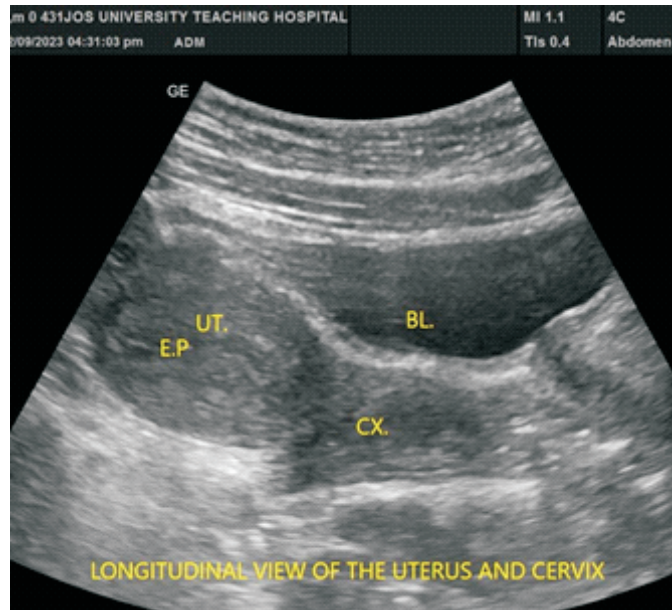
A grayscale transabdominal longitudinal sonogram demonstrating a normal sized uterus (UT) with a convex fundus. The endometrial plate (EP), the cervix (CX) and the urinary bladder (BL) were also demonstrated.
